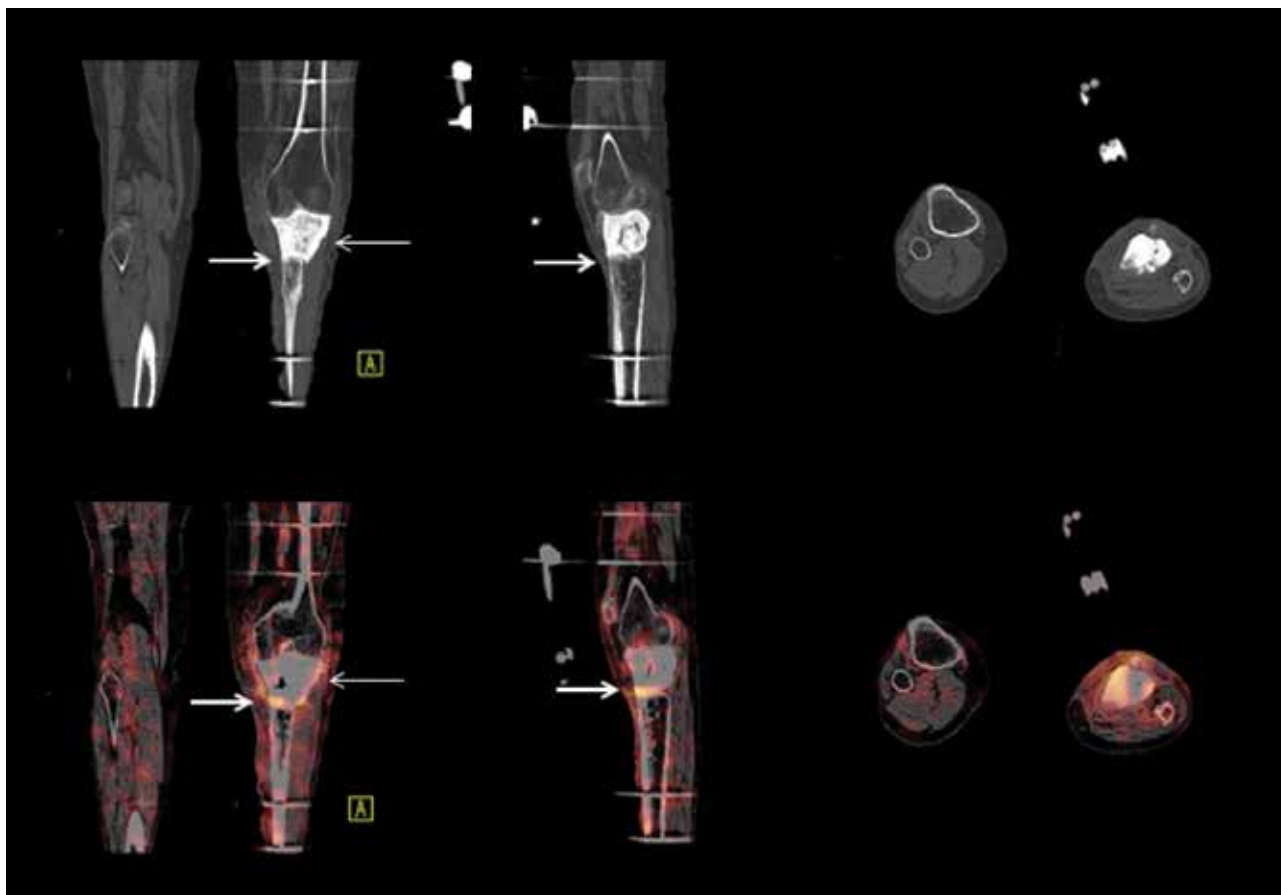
CT and fused SPECT/CT images of the 5-hour post-injection study. CT shows radiodense mass at the proximal end of the tibia (*thin arrow*), which reflects the cement spacer inserted following resection of the majority of the tibial head. The cement fits between the femoral articular surface and the upper end of the tibial shaft. The left knee joint space is eliminated. The tibial tuberosity is still intact and shows osteoporosis, but no sclerosis. The tibial shaft distal to the cement spacer shows cortical thinning with focal calcifications in the marrow. Femoral condyles and shaft appear normal. Fused images show small area of mildly increased uptake at the junction of the dense cement spacer and the tibial shaft (*thick arrows*), as well as mild uptake in the adjacent soft tissue, which is probably related to reactive changes secondary to soft tissue inflammation following surgery and immobilization.
